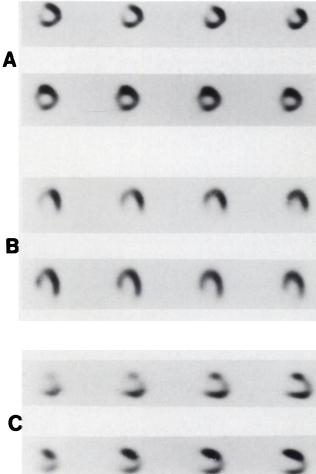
Corresponding SPECT sections of stress (upper) and 3-hr delayed (lower) images. (A) Short-axis. (B) Horizontal long-axis. (C) Vertical long-axis. Myocardial bridging of the LAD causes extensive reversible anteroseptal ischaemia.
